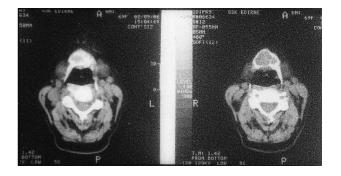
CT scans of the neck showing a cystic structure within the hyoid bone.
